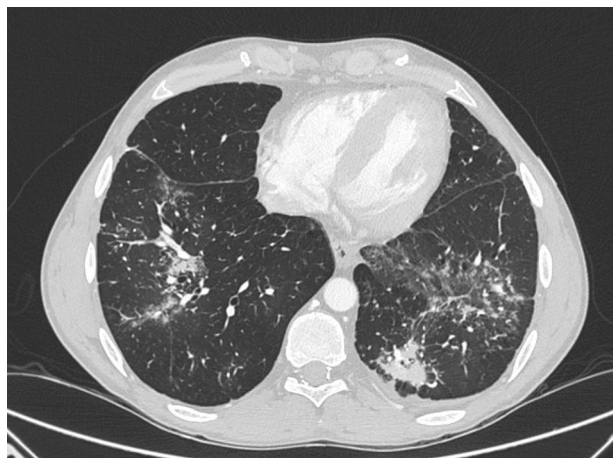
Pulmonary computed tomography showing patchy areas of consolidation and ground-glass opacities 1 month after COVID-19 respiratory symptoms onset.
